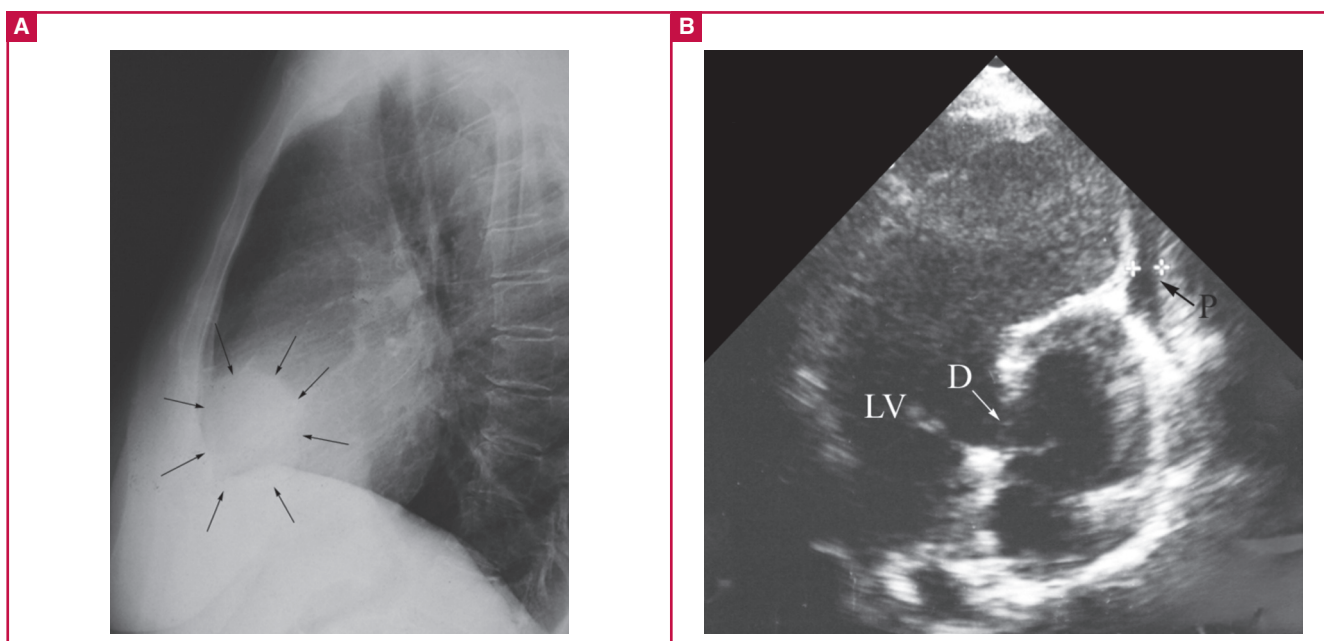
(A) Pre-operative chest X-ray (lateral projection) visualising the aberrant contour of the LV pseudo-aneurysm. (B) Pre-operative transthoracic echocardiography demonstrating the anterolateral pseudo-aneurysm (LV: left ventricle, D: defect, P: pericard).
